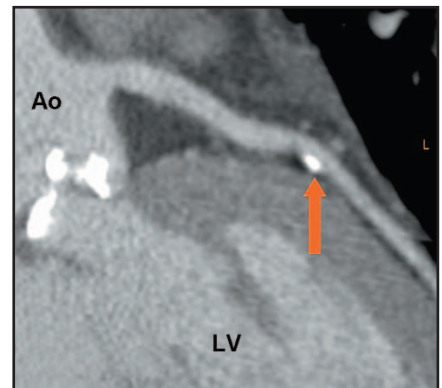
This CTA image reveals the primarily calcified, nonobstructive plaque (arrow) in the midportion of the left anterior descending artery. (Ao = aorta; LV = left ventricle.)
